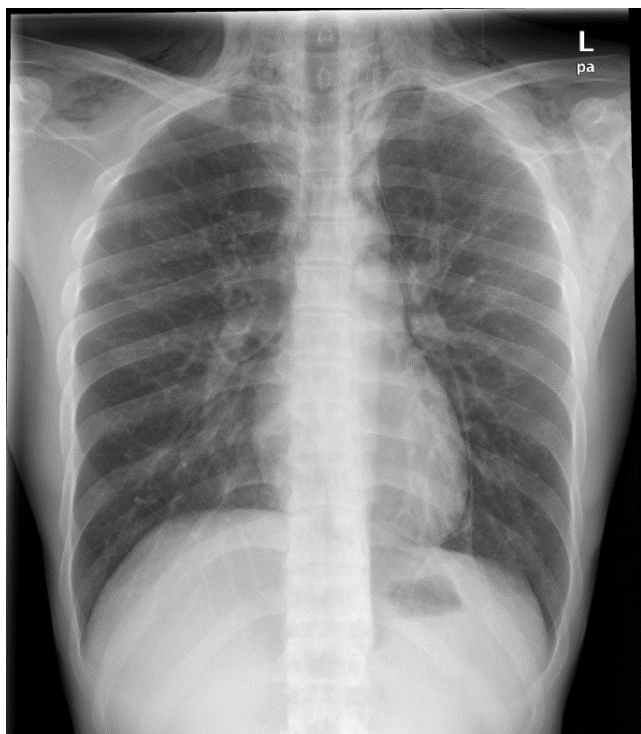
Chest Radiograph. Left apical pneumothorax with air-shadow highlighting the left mediastinal border and cardiac silhouette, indicating pneumomediastinum. Air shadows over bilateral sides of the neck (left more than right) indicating subcutaneous emphysema.
